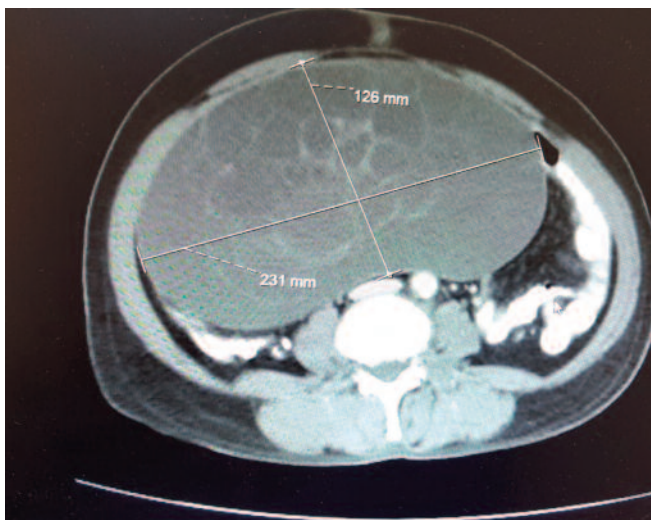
Pelvic computed tomography showing a multicystic lesion measuring 26×23×12 cm with a solid component
